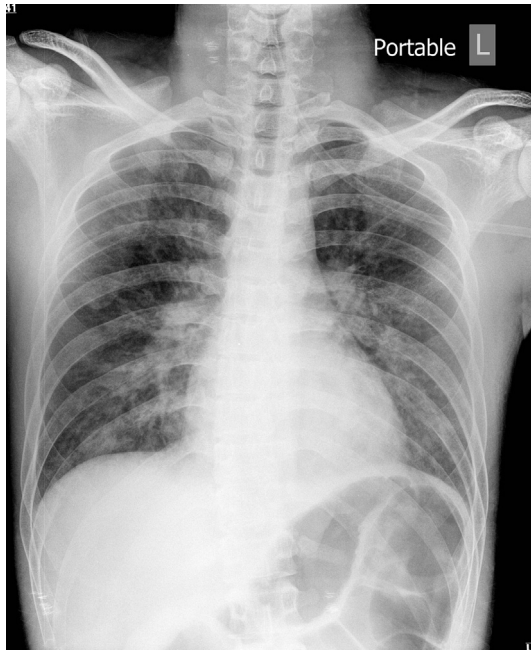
The chest X-ray revealed interstitial infiltration of the bilateral lower lobe of the lungs.
